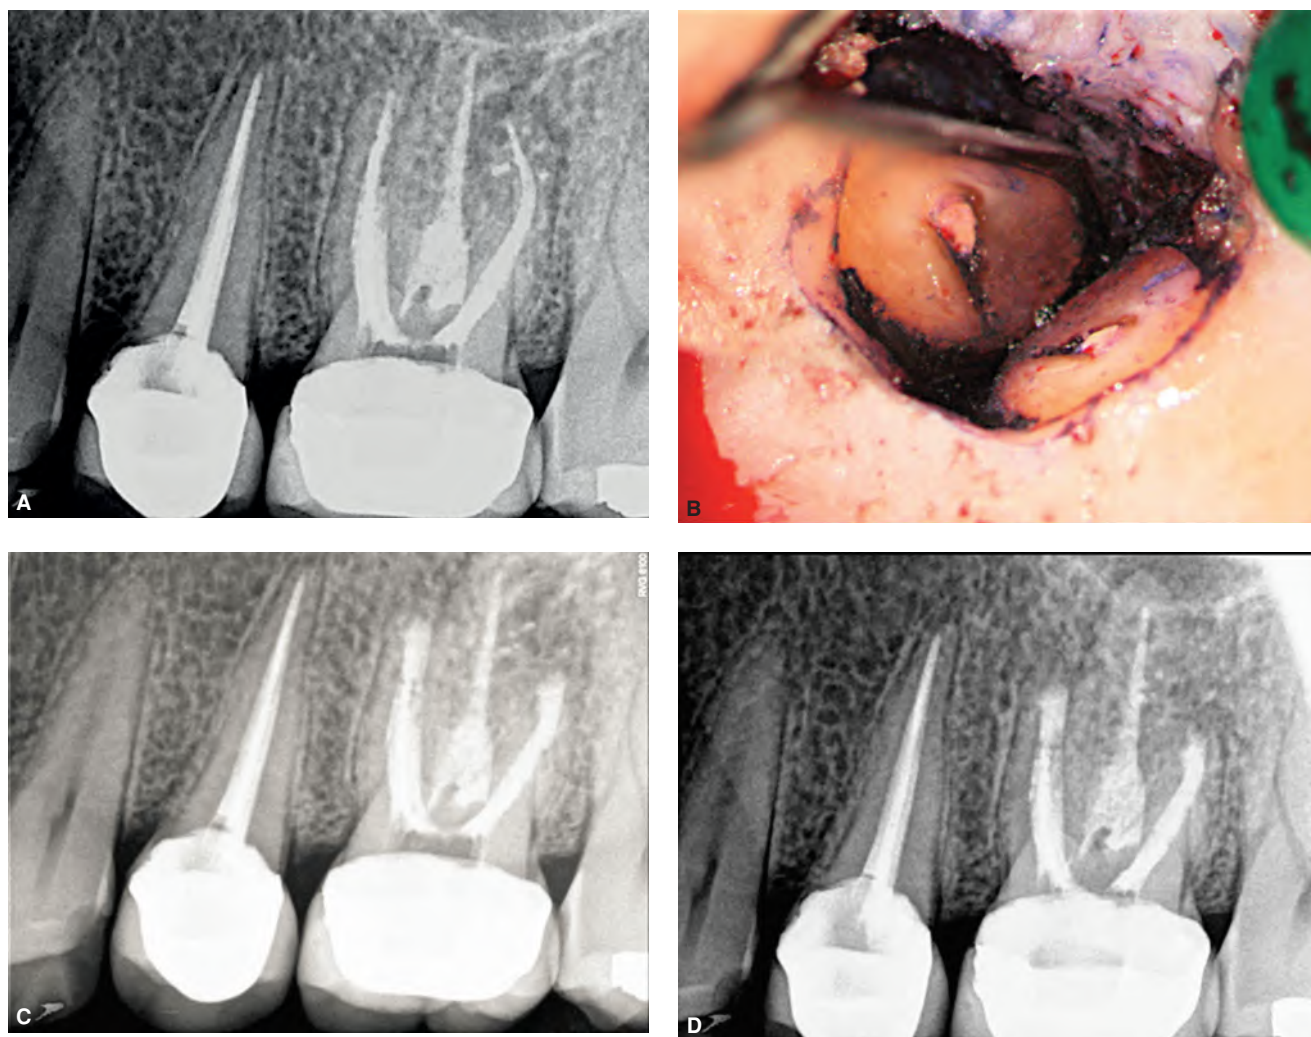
A. Periapical radiolucency around distobuccal root of a restored endodontically treated maxillary molar. B. During endodontic surgery, an incomplete fracture was seen. The two roots were root-end sealed with MTA. C. Immediate postoperative radiograph showing the two root-end fillings. D. Six-month postoperative radiograph showing evidence of progressive periapical healing around the DB root. (Courtesy of Dr. Spyros G. Floratos, Athens, Greece.)
